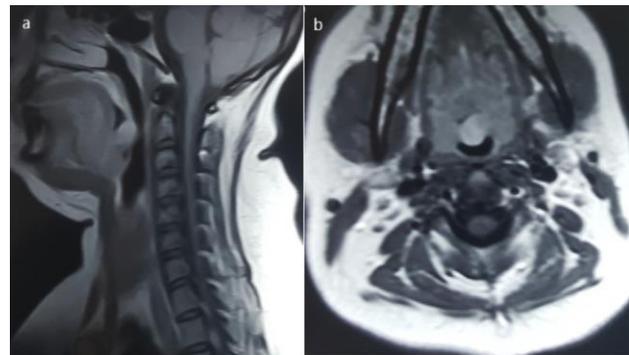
MRI scan (Gadolinium enhanced) with both sagittal view (a) and axial view (b), showing a soft tissue density lesion (LT) measuring 12 in transverse, 13 mm in antero-posterior and 16 mm in cranio-caudal direction, arising from left side of the tongue base and projecting into the oropharynx.
